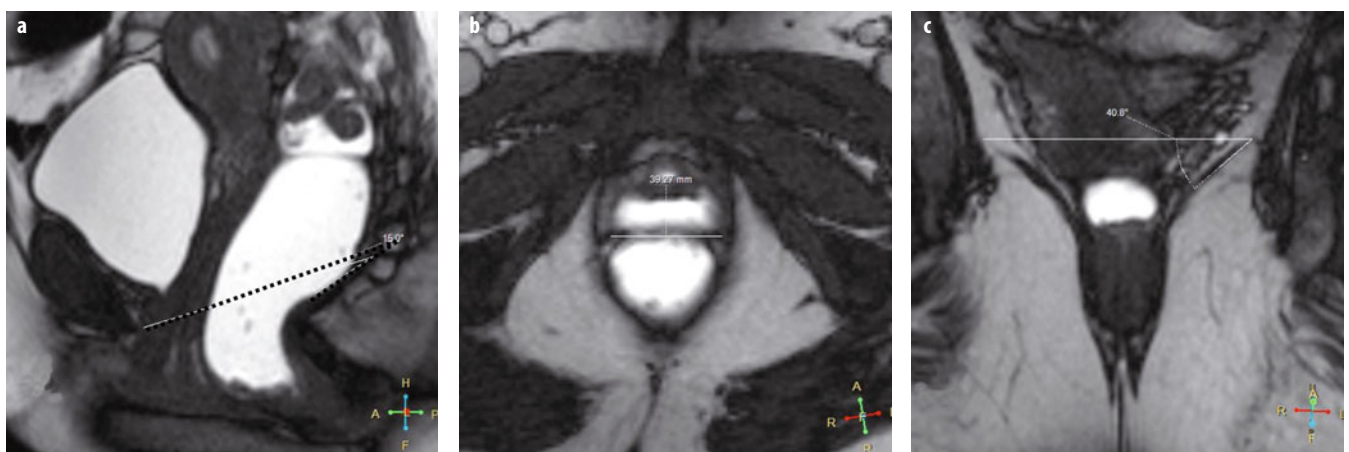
a-c. Dynamic T2-weighted magnetic resonance images in the three orthogonal planes; all images are acquired during maximum straining. a Levator plate angle (*dashed line*), b width of levator hiatus (*solid line*), c iliococcygeus angle (*solid line*)
